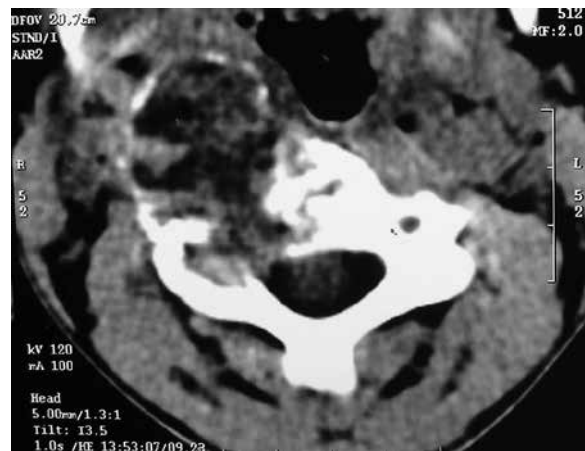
Computed tomography scan of the cervical spine revealing an expansive osteolytic lesion in C3, with destruction on its right pedicle and direct compression of the spinal cord.
